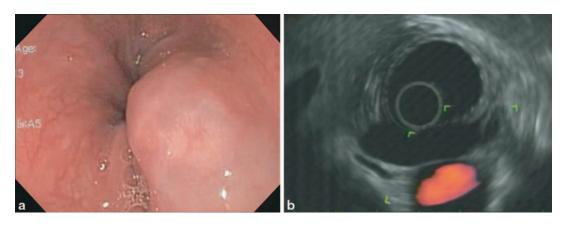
Esophageal granular cell tumor. a Endoscopic examination reveals a small, firm nodule with a yellowish hue located in the distal esophages. b Endosonographic appearance of a small esophageal granular cell tumor
